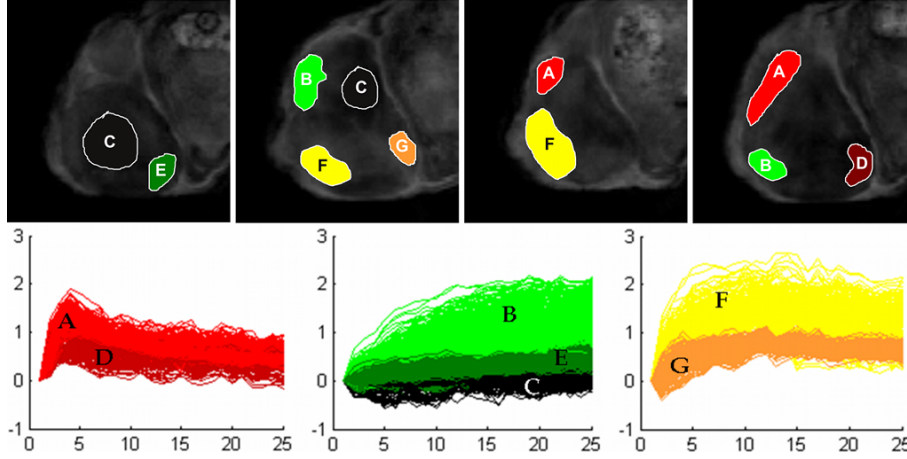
Sample regions used for SVM training. To account for tumour heterogeneity seven classes (A-G) were chosen by a-priori knowledge. Source data used to select the sample regions (TOP), and the relative DCE-MRI curves of the whole training set are reported (BOTTOM).
